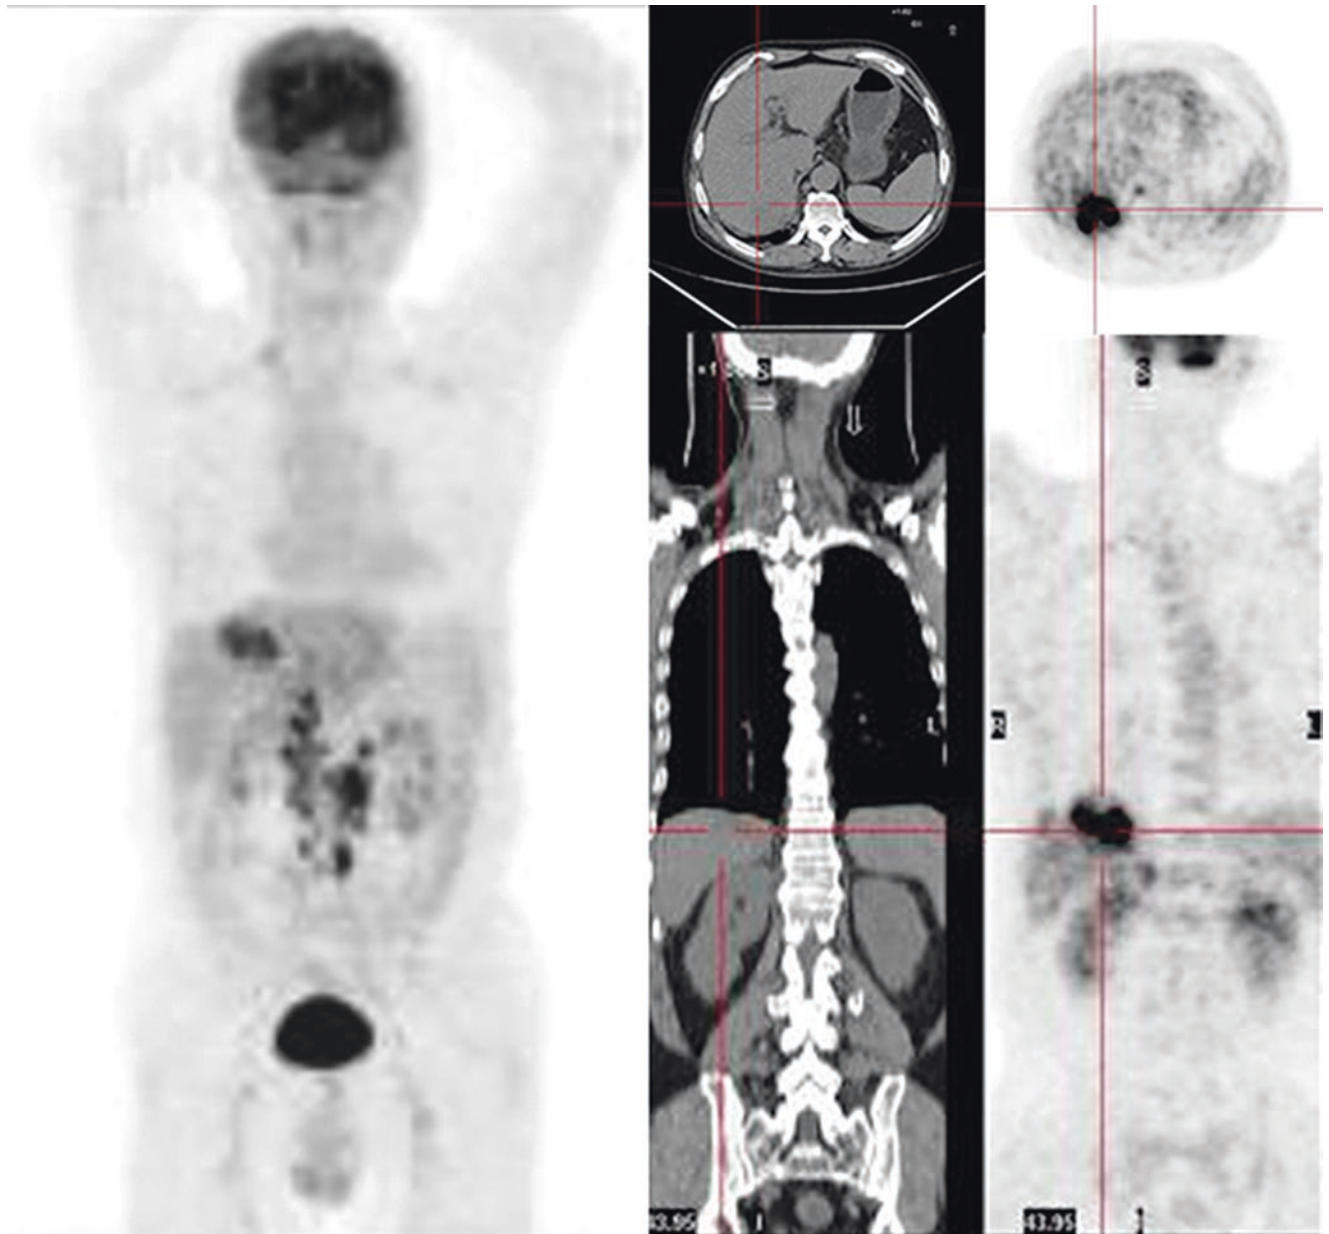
PET/CT—The density of the right posterior lobe of the liver decreased slightly, metabolism increased, which maybe malignant lesions
